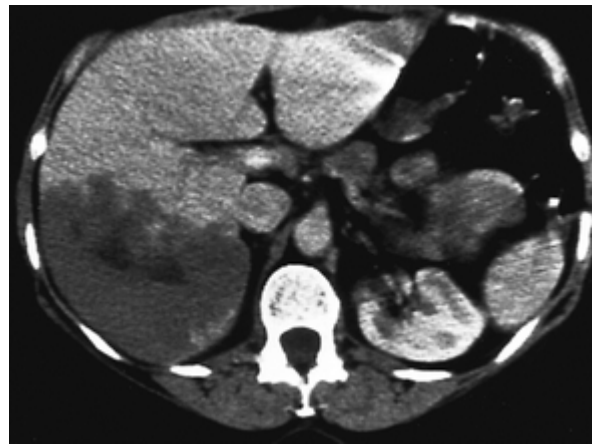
Cystic hepatocellular carcinoma in 60-year-old man with known hepatocellular carcinoma. CT scan shows multiple low-attenuation masses in liver. (Brookline (2011).
